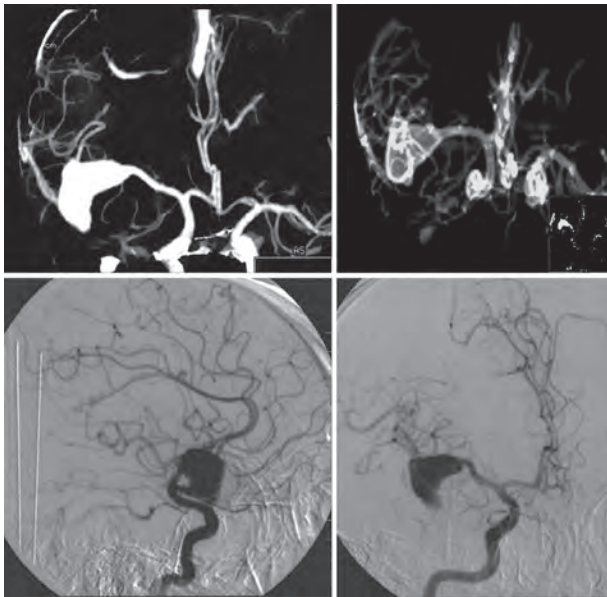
CTA and DSA—Rt. MCA fusiform aneurysm
